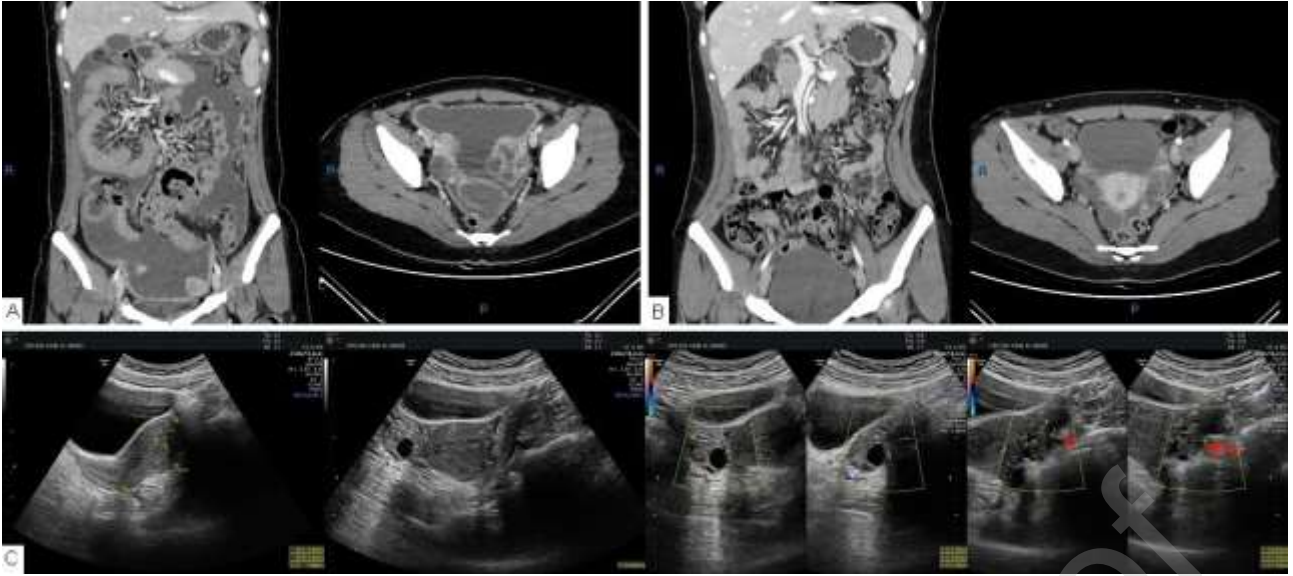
(A) Contrast enhanced CT scan at diagnosis that shows ascites, peritoneal thickening and adnexal complex cystic mass. (B) Contrast enhanced CT scan after therapy that shows resolution of ascites, reduction of peritoneal thickening and of adnexal dimensions. (C) Pelvic transabdominal ultrasonography 12 months later shows normal uterus and adnexa.
